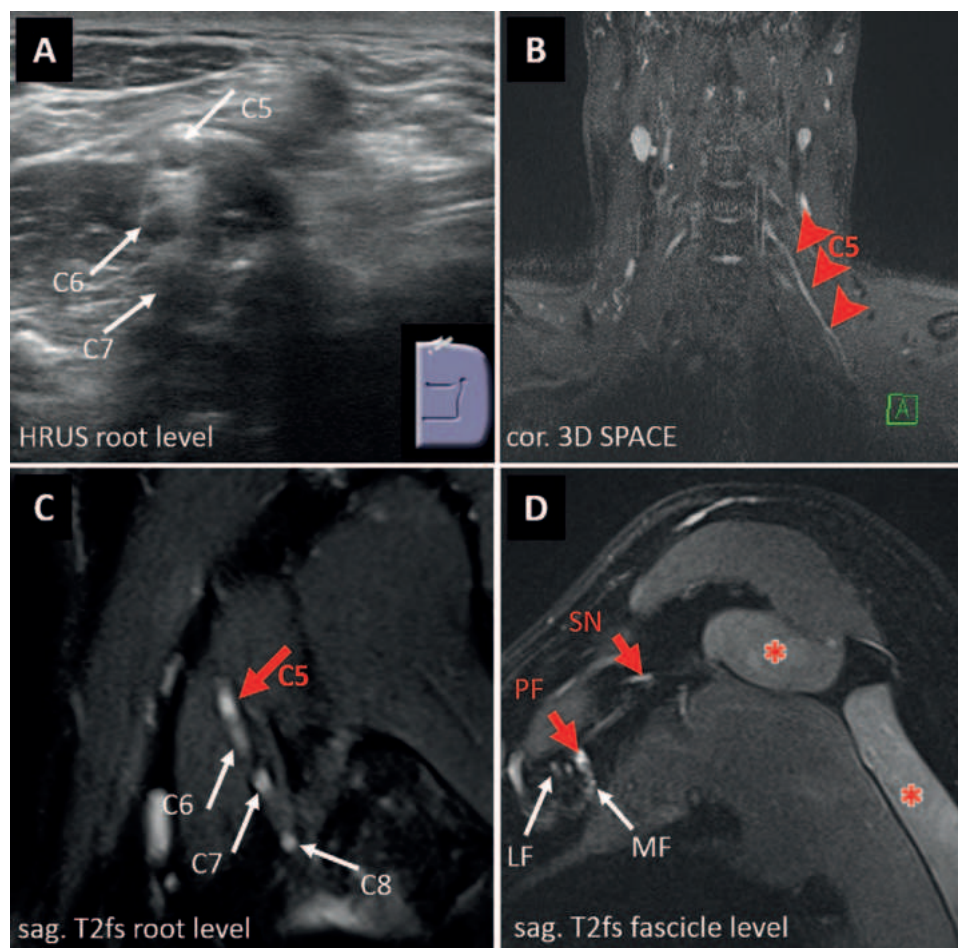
High-resolution nerve US (HRUS; A) sensitivity is inferior to that of MR neurography (MRN; B–D). A 41-year-old male participant presented with weakness to elevate (Medical Research Council grade 2) and hypesthesia of his upper left arm following a motor vehicle crash that occurred 1 month before he underwent imaging. Results of an electrophysiologic examination suggested an upper plexus injury with denervation activity in the participant's supraspinatus and infraspinatus and deltoid muscles. (A) HRUS image shows a normal appearance without suspicious changes in echogenicity or nerve enlargement in the supraclavicular plexus elements, including the extraforaminal nerve roots. (B) MRN image shows a mild elongation of the C5 nerve root, and the C5 root (arrowheads) showed a signal intensity increase and a slight enlargement at (C) T2-weighted fat-saturated (T2fs) imaging (red arrow on C), contrasting with the normal-appearing roots C6 through C8 (white arrows on C) of the brachial plexus. (D) In the infraclavicular plexus segment, the pathologic T2-weighted signal intensity increase was continued into the axillary nerve portion of the posterior fascicle (PF) and into the suprascapular nerve (SN; red arrows on D). Image shows a diffuse T2-weighted hyperintense denervation edema within the supraspinatus and infraspinatus muscles (*). The image shows normal signal intensity (white arrows on D) in the lateral fascicle (LF) and medial fascicle (MF). cor. = coronal, sag. = sagittal, SPACE = Sampling Perfection with Application optimized Contrasts using different flip angle Evolution, T2fs = fat-saturated T2-weighted sequence, 3D = three-dimensional.
